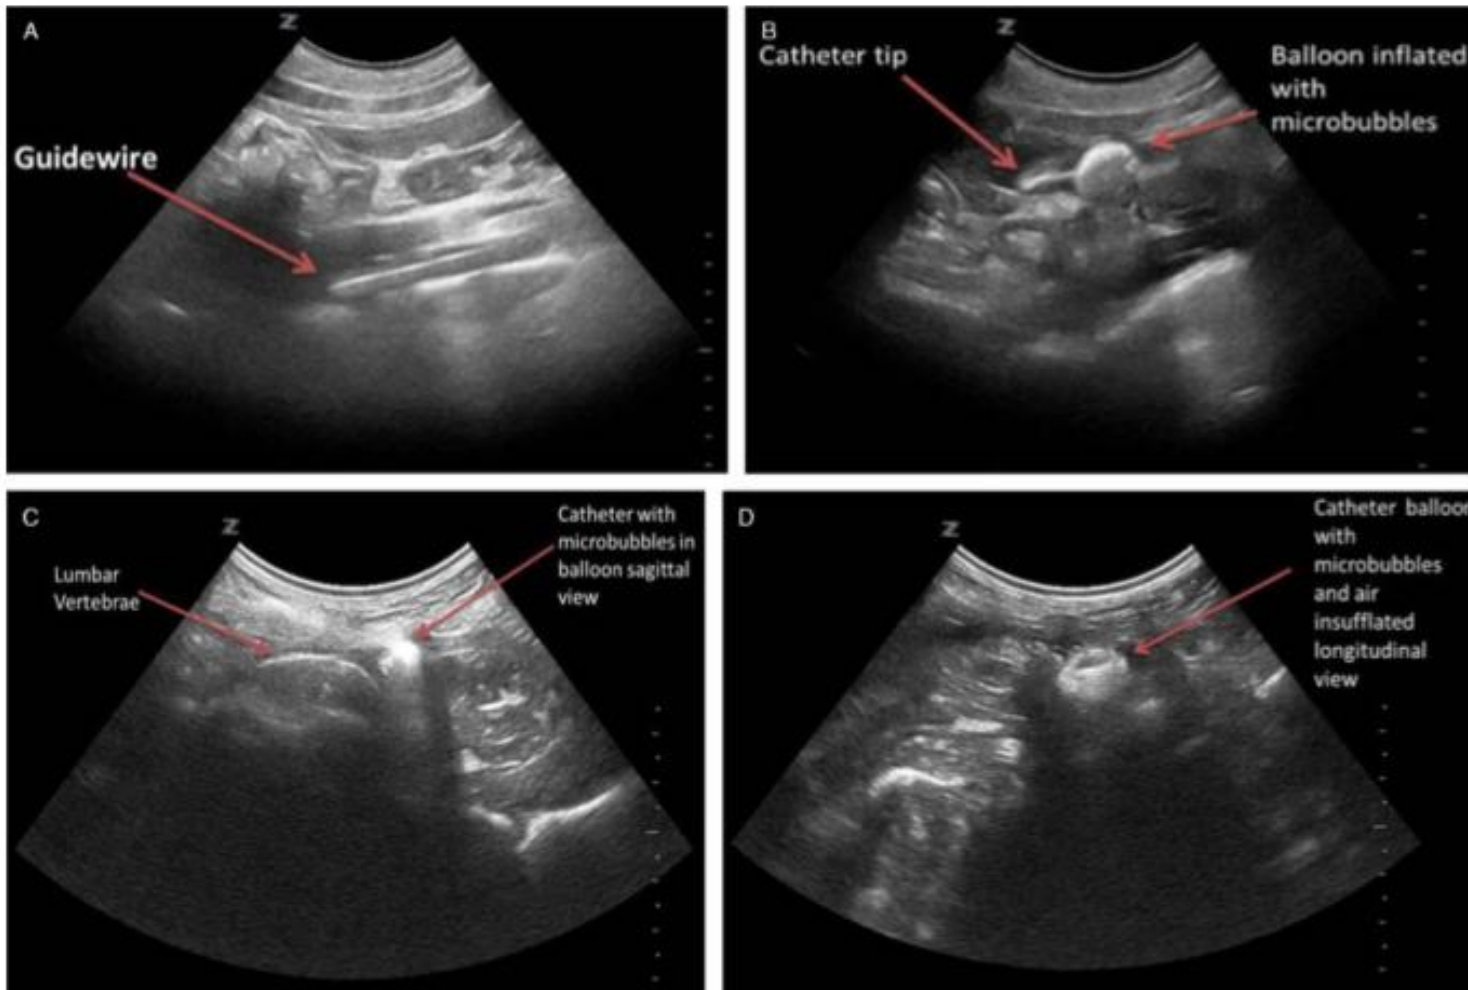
Ultrasonography images of guide wire and catheter. *A*, Guide wire visualized under ultrasonography longitudinal view within Zone III of the aorta. *B*, Longitudinal view of Coda catheter tip and balloon inflated with microbubbles within Zone III. *C*, Sagittal view of Coda catheter tip and balloon inflated with microbubbles within Zone III. *D*, Contrast-enhanced ultrasonography longitudinal view of balloon inflated with microbubbles and air within the aorta.
